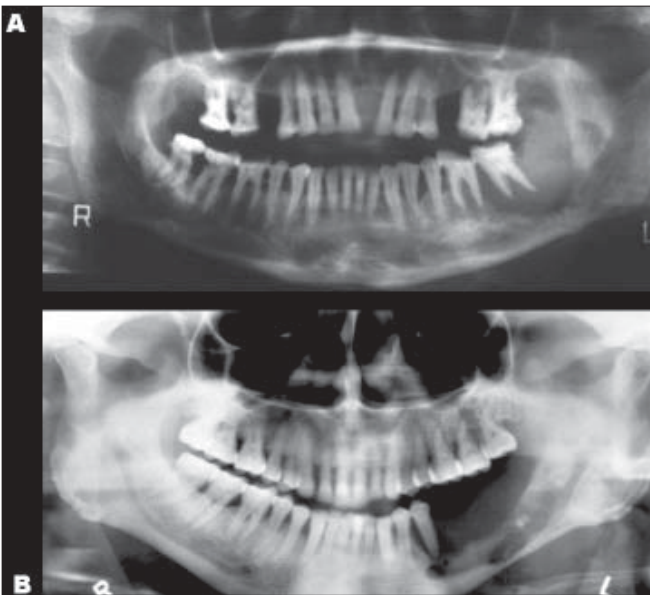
Panoramic radiographs from patients having advanced oral cancer with secondary invasion of the mandible. Note the “saucerization” of the upper surface of the left side of the mandible in both of these cases. Both cases also show “floating teeth” where supporting bone has been resorbed. Case B shows invasion of the mandibular canal.
